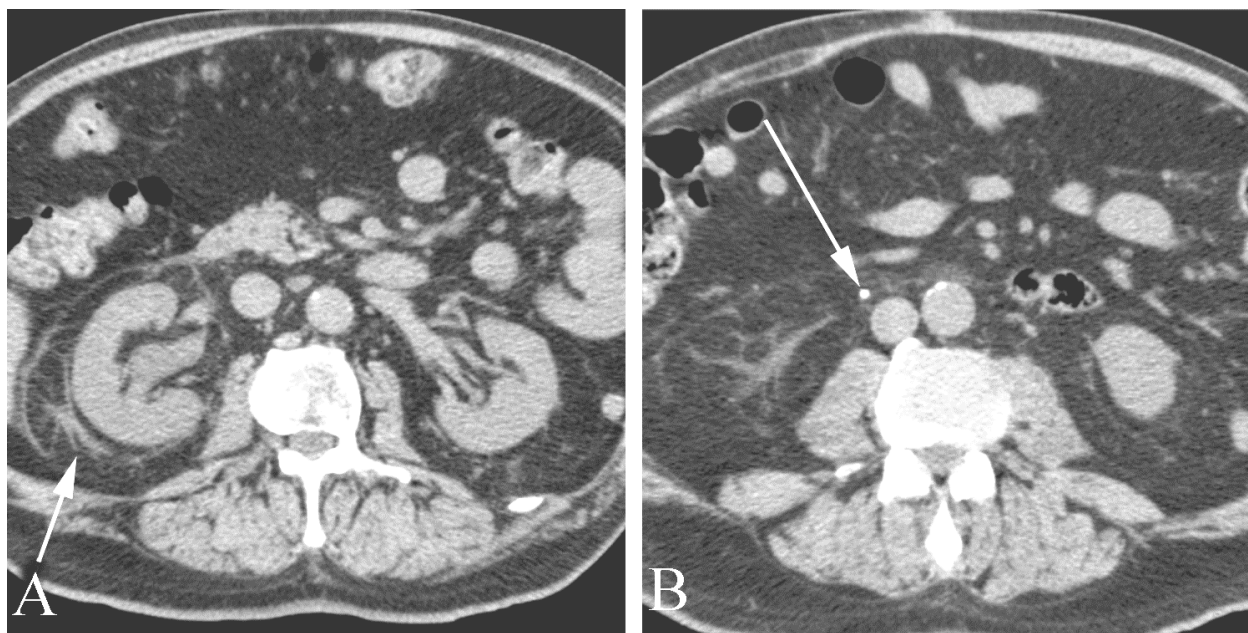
Renal stone disease in an 82 year old man with acute right flank pain. A. CT-KUB at the level of the kidneys shows perinephric stranding (arrow). B. CT-KUB at the level of the proximal ureter shows a calcified stone (arrow).
